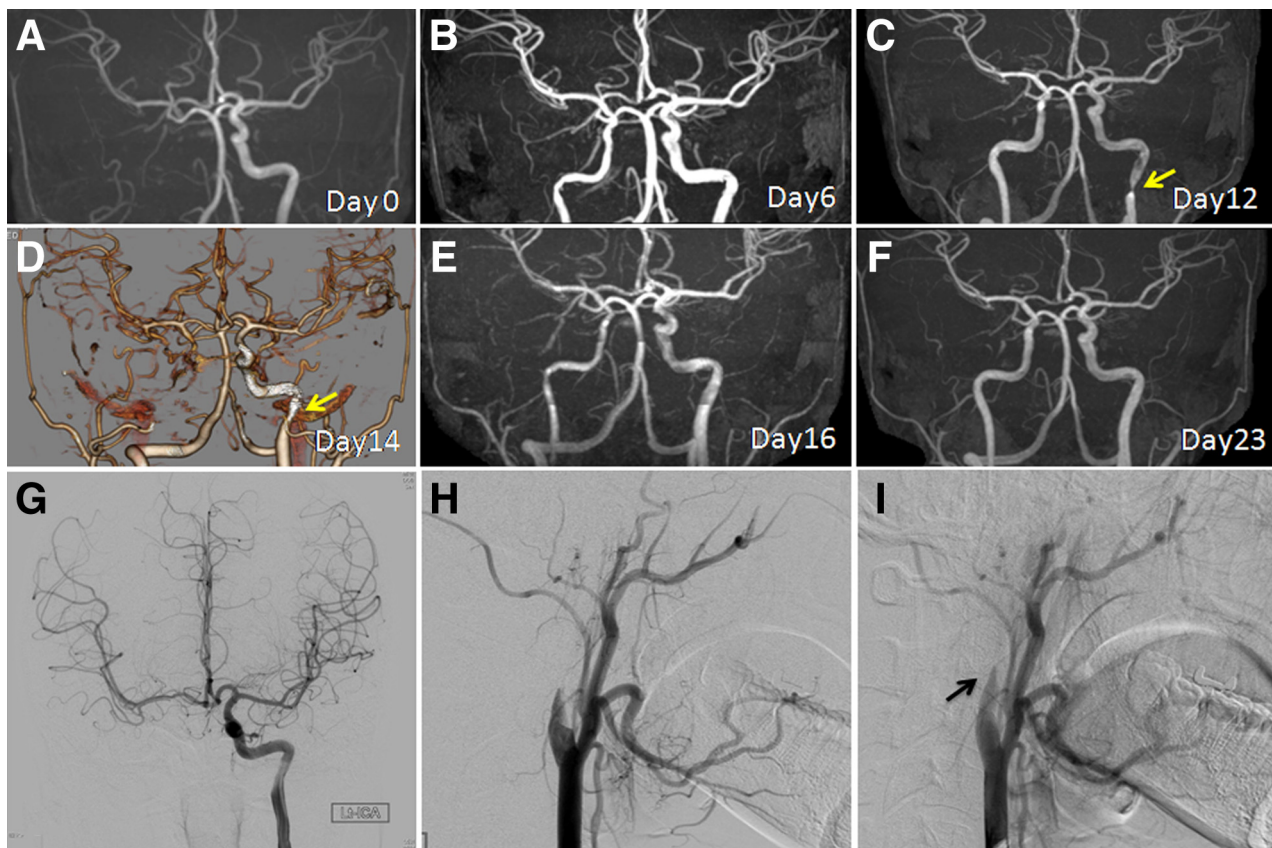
(A-F) Temporal profile of MR angiography (A-C, E, and F) and 3-dimensional computed tomography angiography 14 days after the onset (D). MR angiography at the onset (A), 6 days (B), 12 days (C), 16 days (E), and 23 days (F) after the onset. Temporal profile of reversible bilateral ICA vasospasm before (A-D) and after (E and F) the interventional local intra-arterial injection of a calcium channel blocker. The site of left ICA vasospasm is indicated by arrows in (C) and (D). (G-I) Anteroposterior view of the left ICA injection before treatment, demonstrating collateral cross flow to the right ICA territory. Lateral view of the right common carotid artery injection before (H) and after (I) the interventional local intra-arterial injection of a calcium channel blocker. Abbreviations: ICA, internal carotid artery; MR, magnetic resonance.
